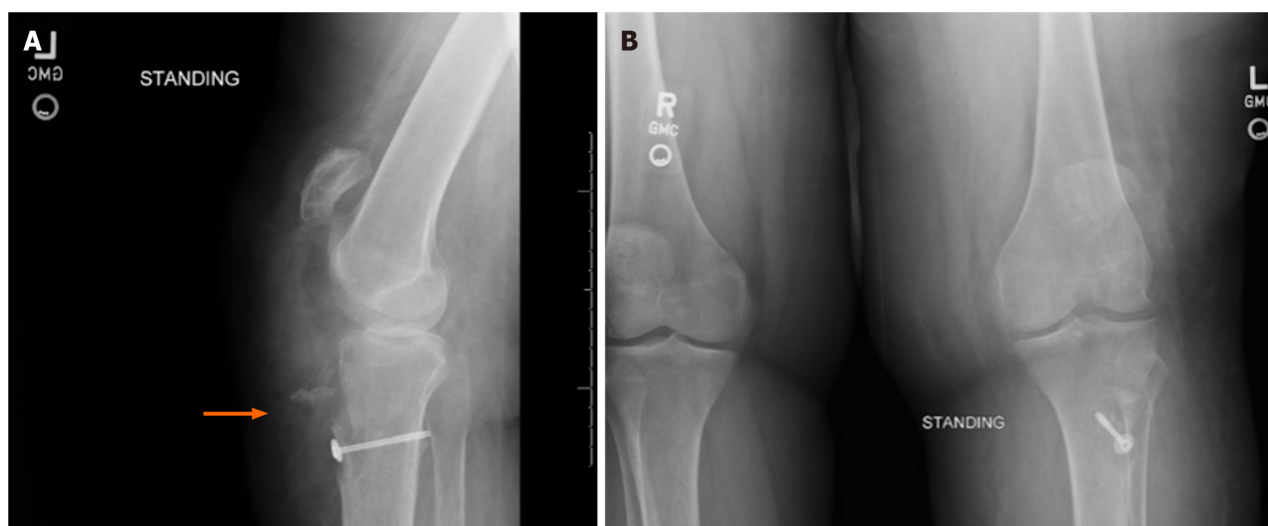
Preoperative plain radiographs. A: Left knee lateral radiograph demonstrating patella alta and tibial tubercle avulsion fracture; B: Standing Anterior-Posterior radiograph bilateral knees. Note patella alta of left knee with normal patellar height of right side.
